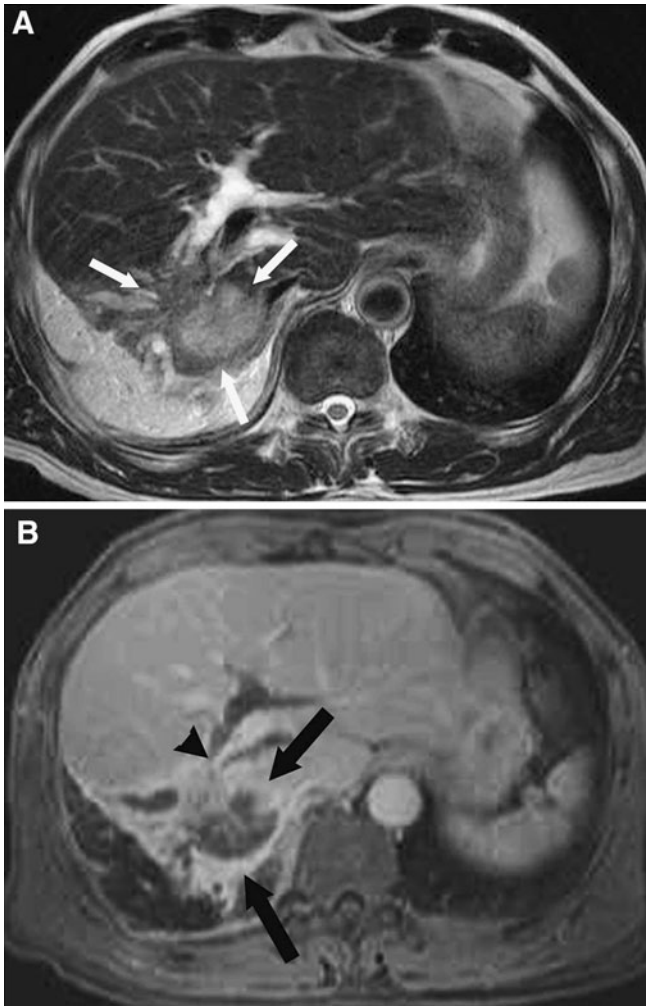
Cholangiocarcinoma associated with RPC in a 65-year-old man who complained of abdominal pain and fever. A T2-weighted TSE MR image demonstrates slightly high-signal intensity mass (*arrows*). B Contrast-enhanced MR image during the equilibrium phase shows a thin enhancement at the periphery of the mass (*arrows*). The mass located in the same lobe as the hepatic atrophy and the portal vein obliteration (*arrowhead*). The diagnosis of cholangiocarcinoma was made by percutaneous liver biopsy.
